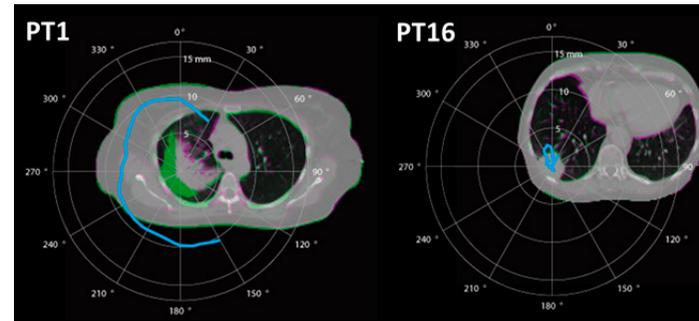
The  $\Delta$ WEPL (blue line) for patient 1 and 16 as a polar plot overlaid on the image registration for the breath-hold CT scans. The green color represents the breath-hold CT at the planning stage, the magenta the breath-hold CT scan at the end of the treatment and the greyscale colors represents perfect match between the two breath-hold CT scans.
